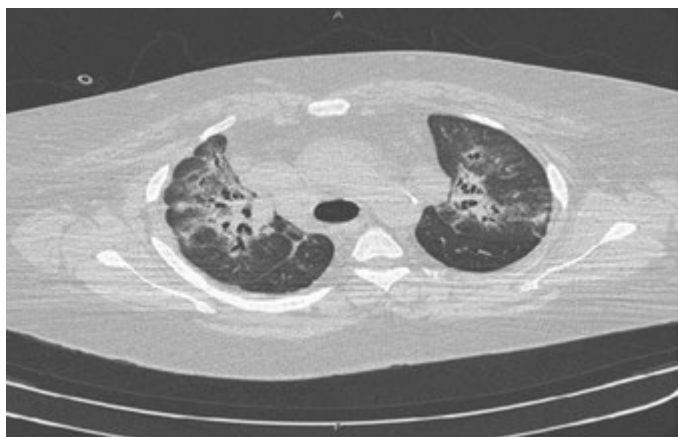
High-resolution CT scan of the chest from the upper lobe area, which is more commonly affected in sarcoidosis, demonstrating fibrotic changes including traction bronchiectasis and honeycombing.
